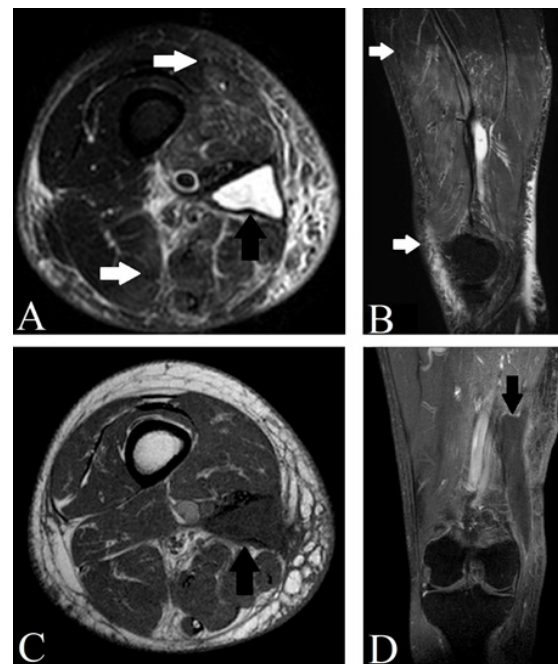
T2 STIR sequence MRI in axial (A), and sagittal (B) sections demonstrating a radiation-induced myositis (white arrows) and collection (black arrow). T1 sequence MRI in axial section (C), and T1 SPIR with contrast coronal section (D) demonstrating the collection (black arrow).
